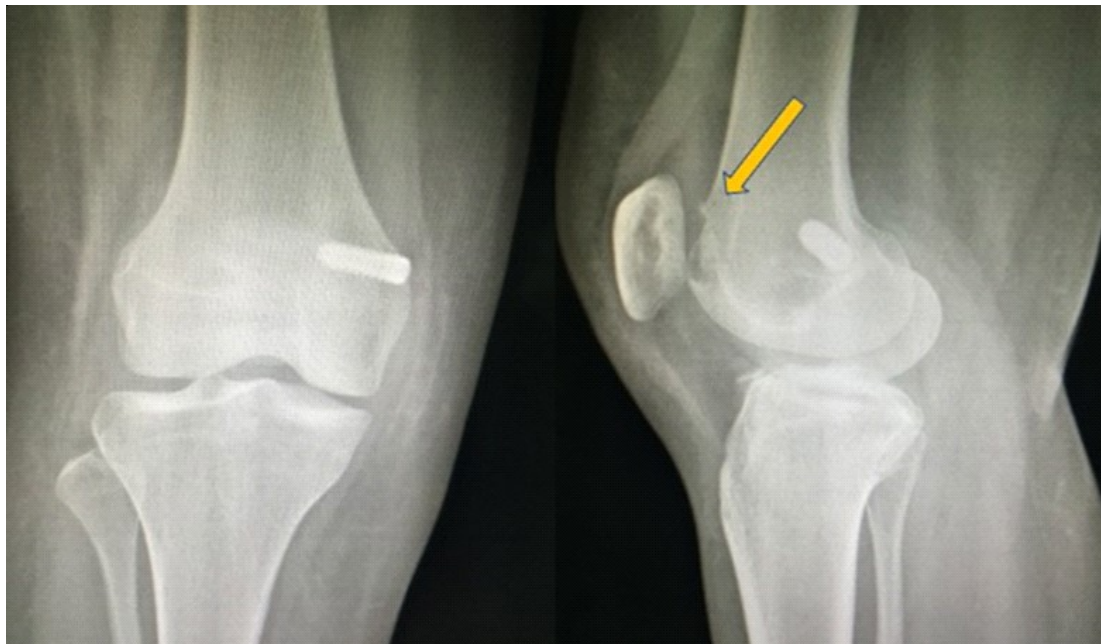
Immediate post operative radiographs showing MPFL reconstruction and evidence of trochleoplasty indicated by the arrow
